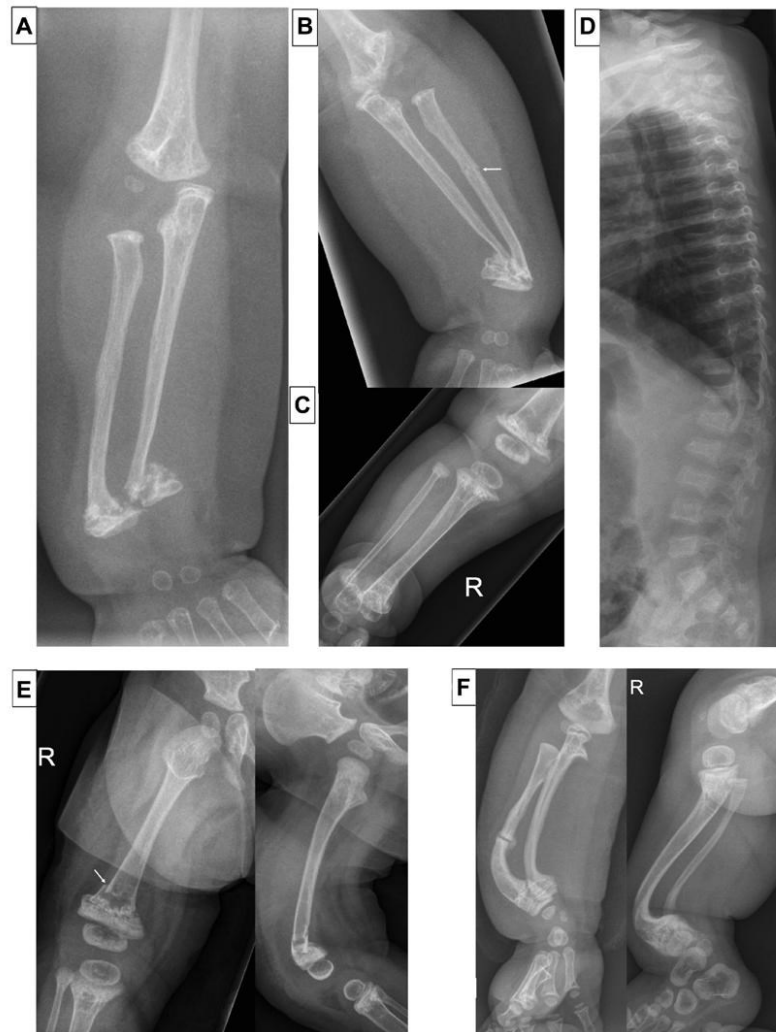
Selected radiographs from a skeletal survey (aged 6 months). (A) AP right forearm. (B) AP left forearm. (C) AP right leg. There is generalised reduction in bone density with relative flaring of the metaphyses. There are slightly angulated and displaced transverse fractures at the junction of metaphyses and diaphyses of all imaged bones except the humeri. Note the irregular metaphyseal sclerosis at the fracture sites and also of distal humerus and proximal radius and ulna, where there are no fractures. Symmetrical metadiaphyseal fractures of this nature are uncommon in OI. There is a further minimally displaced fracture of the shaft of the left radius (arrow). (D) Lateral spine: there are multiple vertebral compression fractures. (E) AP and lateral right femur (aged 10 months). Osteopaenia, flared metaphyses and an acute metadiaphyseal junction fracture in a slightly more proximal position than the previous fracture. As in A, note the irregular sclerosis around the healing fracture. Sclerosis (but no fractures) is also seen around the proximal tibial and fibular metaphyses. (F) Lateral right forearm, lateral right leg (aged 31 months). There is significant bowing deformity of the forearm and leg bones. The bones are dense, presumably due to bisphosphonate therapy (note bisphosphonate lines at distal radial and ulnar metaphyses and dense periphery of the tarsal bones). There are healing fractures of the right midradial and distal humeral shafts. OI, osteogenesis imperfecta.
